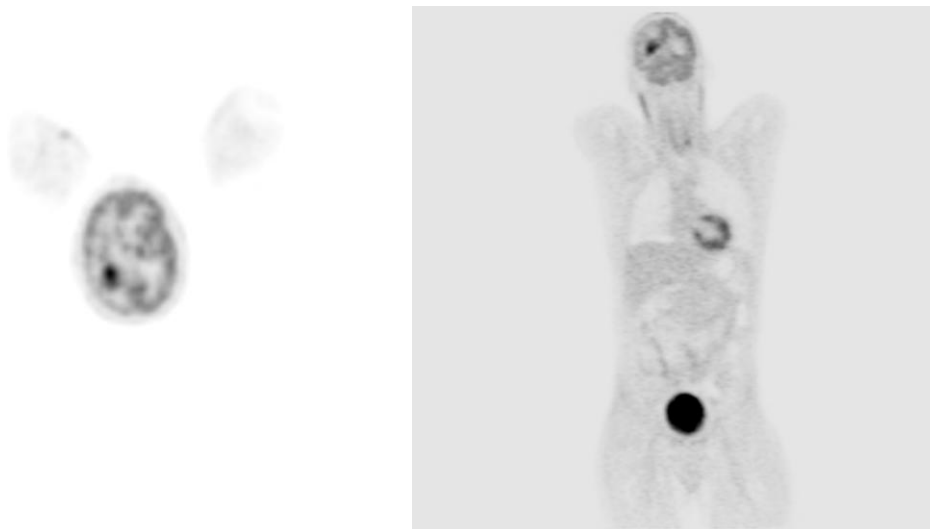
PET Images Axial and Coronal Images show focal FDG uptake in the right parietal lobe corresponding to the mass seen on the MRI. No other areas of abnormal uptake are identified through the remainder of the body. Normal mild myocardial uptake and bladder excretion of the radionuclide are also seen.
